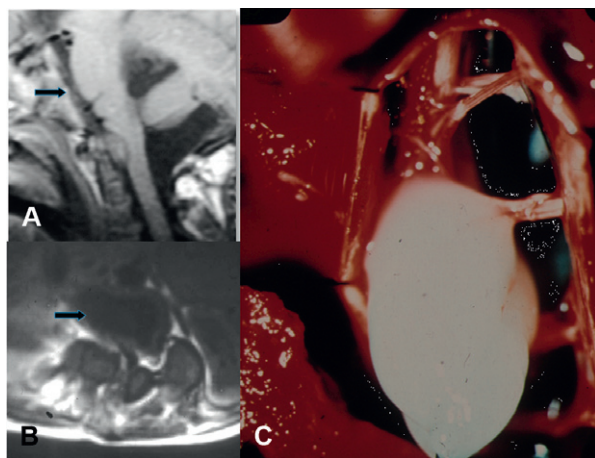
Neurenteric cyst. (A) Sagittal T1-weighted MR. Retroclival neurenteric cyst (arrow). (B) Axial T1-weighted MR. Thoracic neurenteric cyst with a communication between the digestive tube and the dural sac (arrow). (C) Surgical view.
